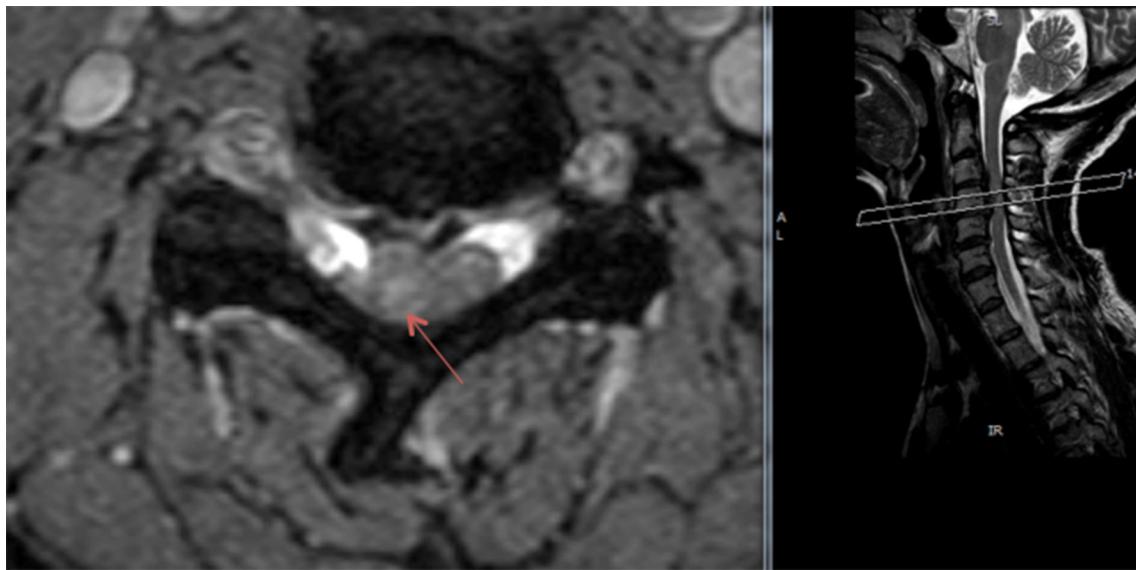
MRI T2—sagittal and axial views. The *arrow* shows the intradural fragment of the disc prolapse severely compressing the spinal cord
